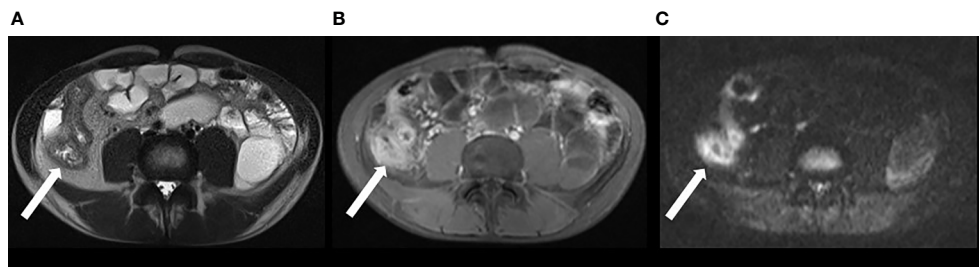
MRI in patient with active CD involving the ileum: there is bowel wall thickening in T2w sequence (A) and increased contrast media uptake in T1w, fat suppressed imaging (B). Inflammation is also revealed by hyperintensity in DWI (C).
